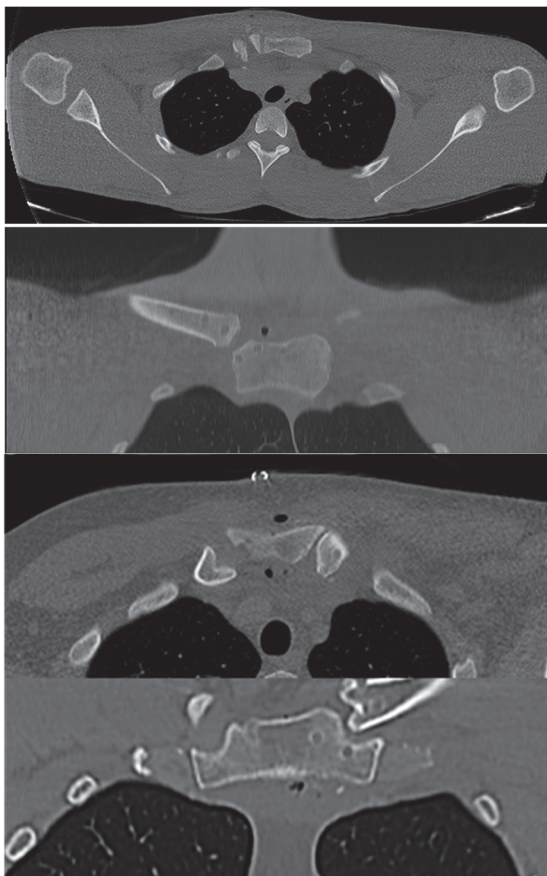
CT scan at 3 months post operation: reduction confirmed on axial and coronal scan on both patients.
